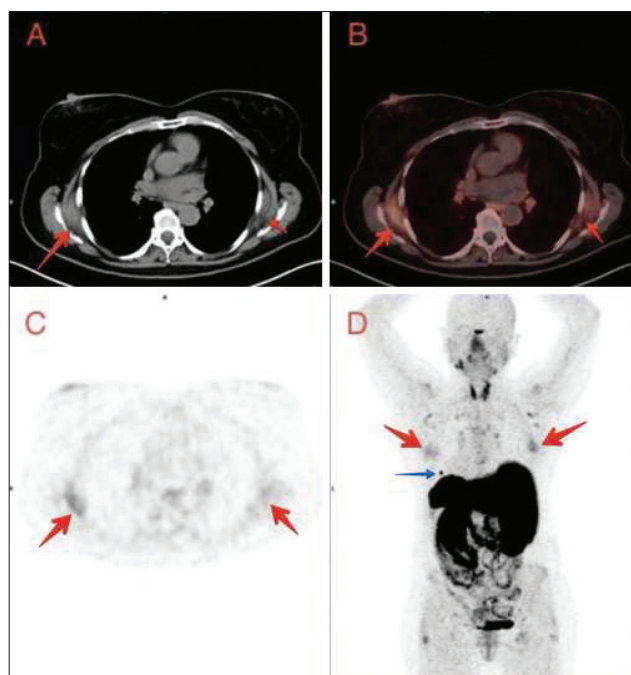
Axial slices of CT (a), PET/CT fusion (b), PET (c) and posterior projection of MIP (d) images showing, bilateral infrascapular soft tissue lesions with slightly Ga-68 DOTATATE uptake (red arrows) are noted. Focal Ga-68 DOTATATE uptake corresponding with accessory spleen (blue arrow) is noted on MIP image.
